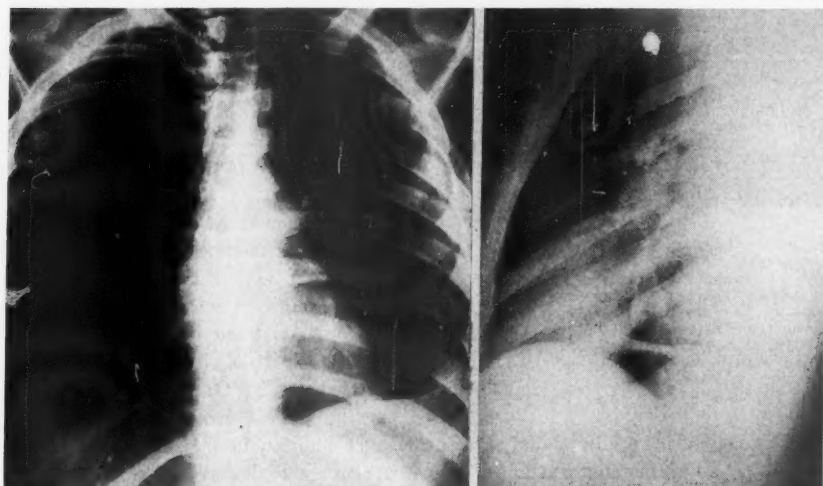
Roentgenograms showing multiple small foreign bodies in chest which have not been removed because they are symptomless.
